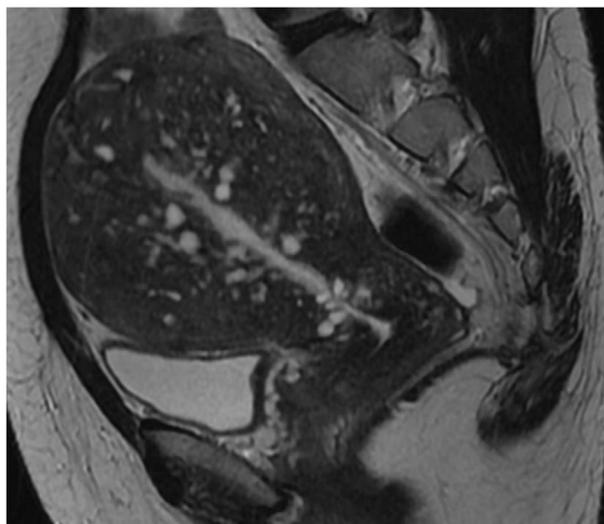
Adenomyosis of the uterus by magnetic resonance imaging.
